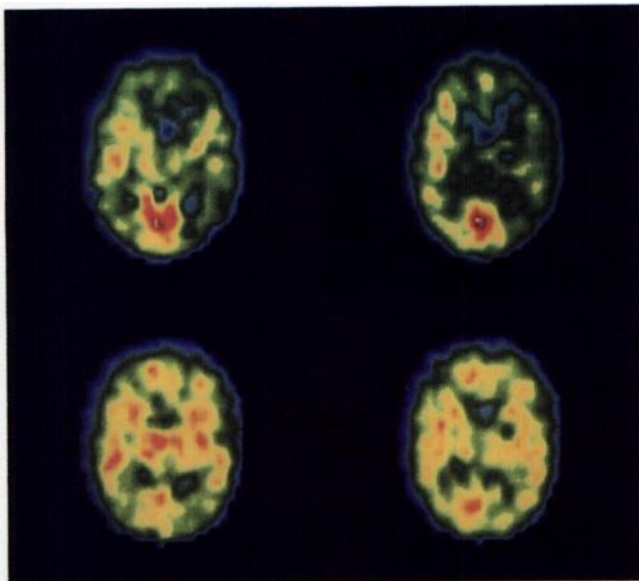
SPECT transverse images before (top) and after (bottom) angioplasty in Patient 4 (see Table 1). There are large areas of severely reduced uptake in the MCA distributions bilaterally on the pre-angioplasty images. Improved rCBF is visually appreciated on the post-angioplasty images with the most remarkable improvement in the left middle cerebral artery distribution. This patient had a residual rCBF deficit in the left frontal region and sustained a small infarct in that location.
